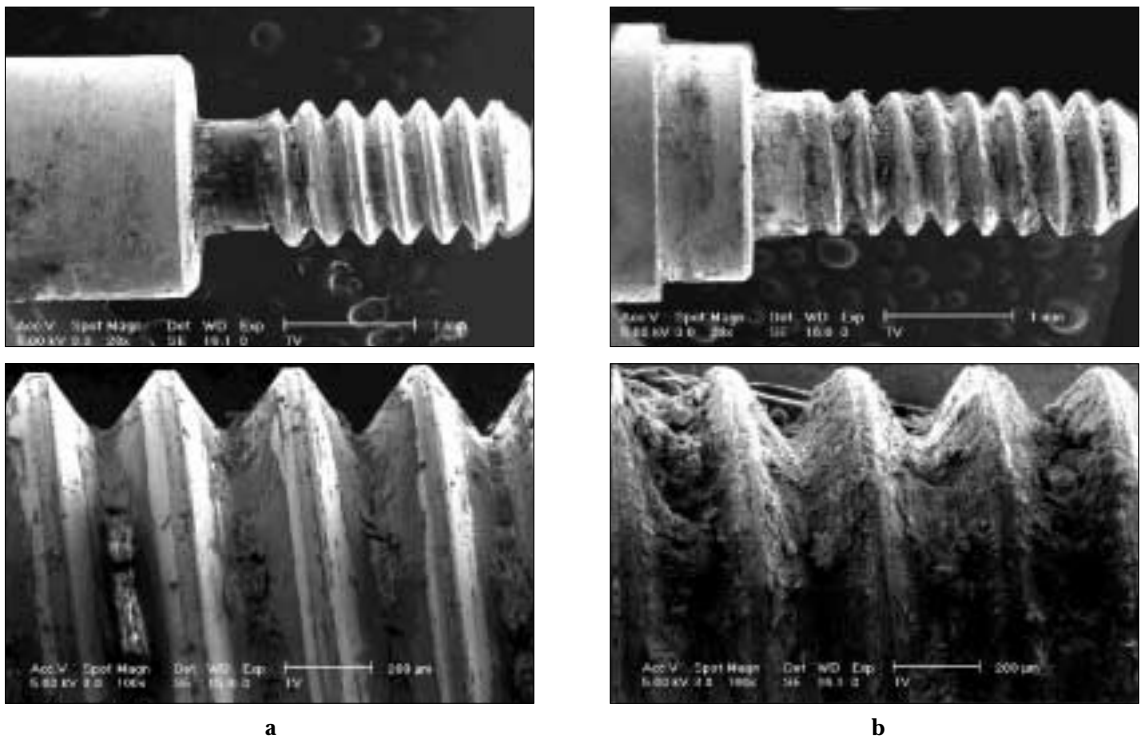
Used retaining screw surfaces before ultrasonic cleansing in SEM. (Magnification $\times 30$, $\times 100$ a: gold screw b: titanium screw)
